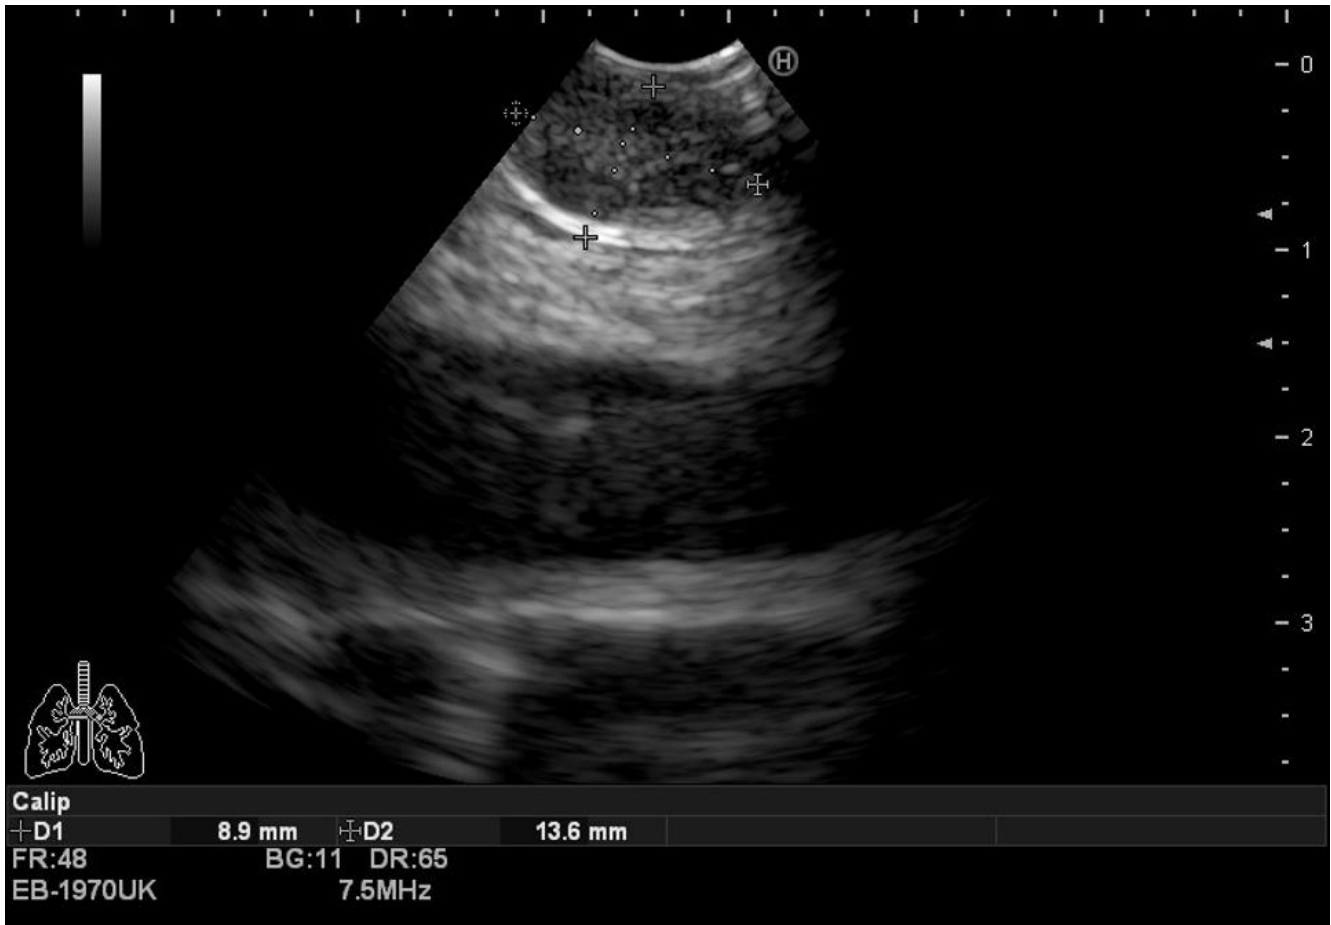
Endobronchial ultrasound (EBUS) imaging of enlarged subcarinal lymph node. Needle aspiration sampling (TBNA) showed evidence of disease relapse.
